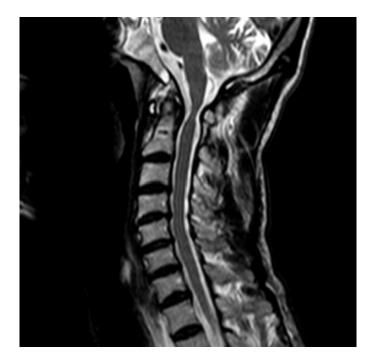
2nd patient pre-operative MRI MRI: Magnetic resonance imaging
